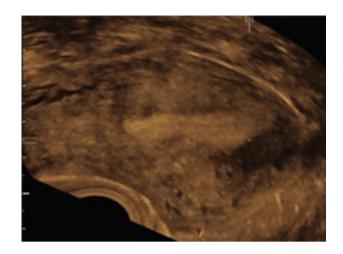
Two-dimensional transvaginal ultrasonography (2D-TVS) of the uterus in the sagittal plane, with the presence of heterogeneity, anechoic lacunae and asymmetric corpus myometrium associated with adenomyosis.
